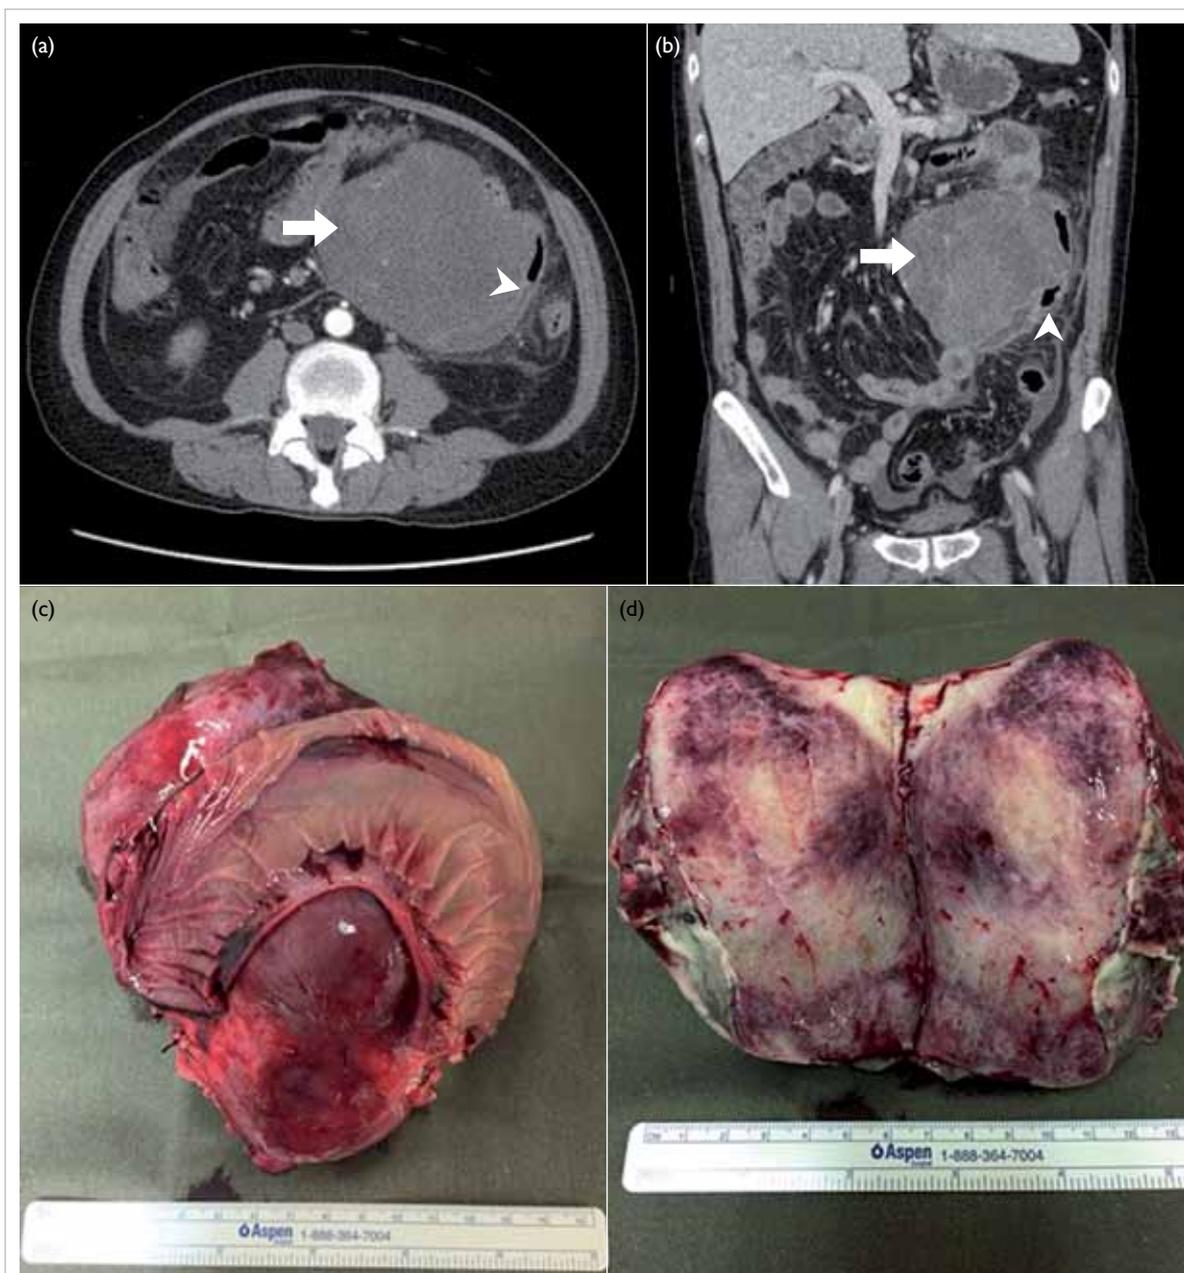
(a) Axial and (b) coronal sections of contrast-enhanced computed tomography showing a 10.2 cm x 11.1 cm x 10.3 cm heterogeneous hypodense mass located at the left abdomen (arrows) with an adjacent rim-enhancing cavity with gas (arrowheads). (c) Tumour located at the mesenteric side of jejunum. (d) White fibrotic cut surface
